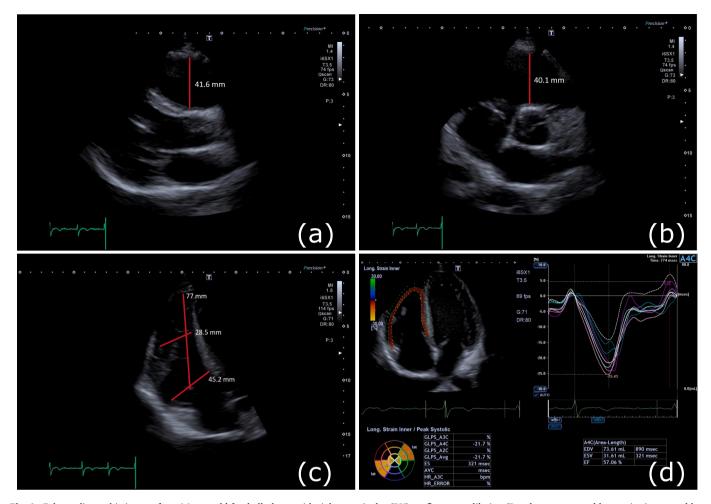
Echocardiographic images for a 16 year old football player with right ventricular (RV) outflow tract dilation (Panel a - parasternal long axis view, panel b – parasternal short axis view), increased RV inlet diameters (Panel c) and normal longitudinal RV strain values (free wall –23.8%, global –21.5%, Panel d).
